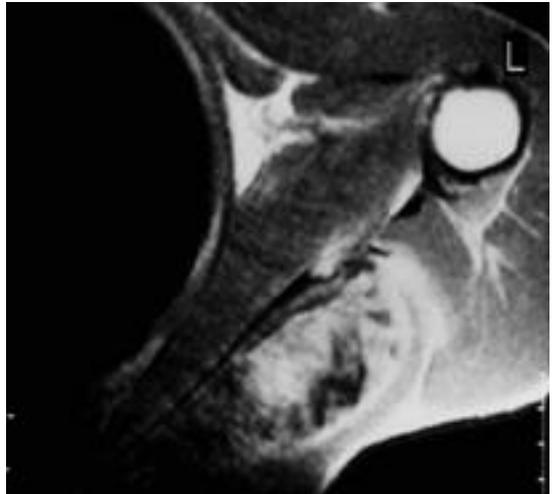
T1-weighted enhanced axial image shows a large mass formation along the posterior border of the scapula with heterogeneous enhancement. Non-enhanced portion is noted at the peripheral portion of the lesion.
